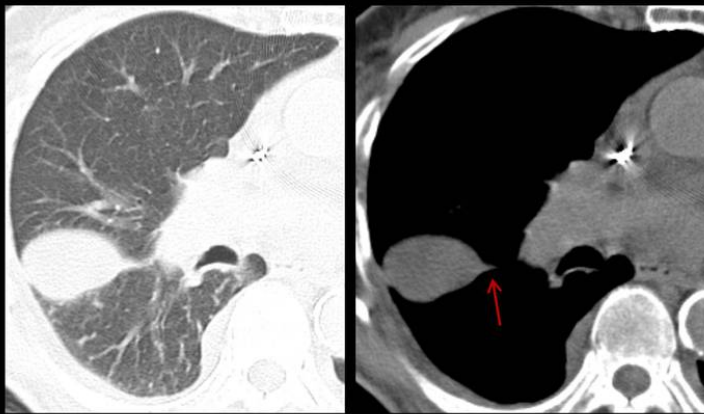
68 year-old patient with congestive heart failure presented with a mass on chest radiography. Lung window CT image shows an apparent parenchymal mass in the right lung. Analysis of sequential soft-tissue window CT images showed a lenticular shape and the relationship of the opaque mass to the plane of the fissure. A beak is visible medially (arrows) and the pseudolesion is of homogeneous fluid attenuation.
